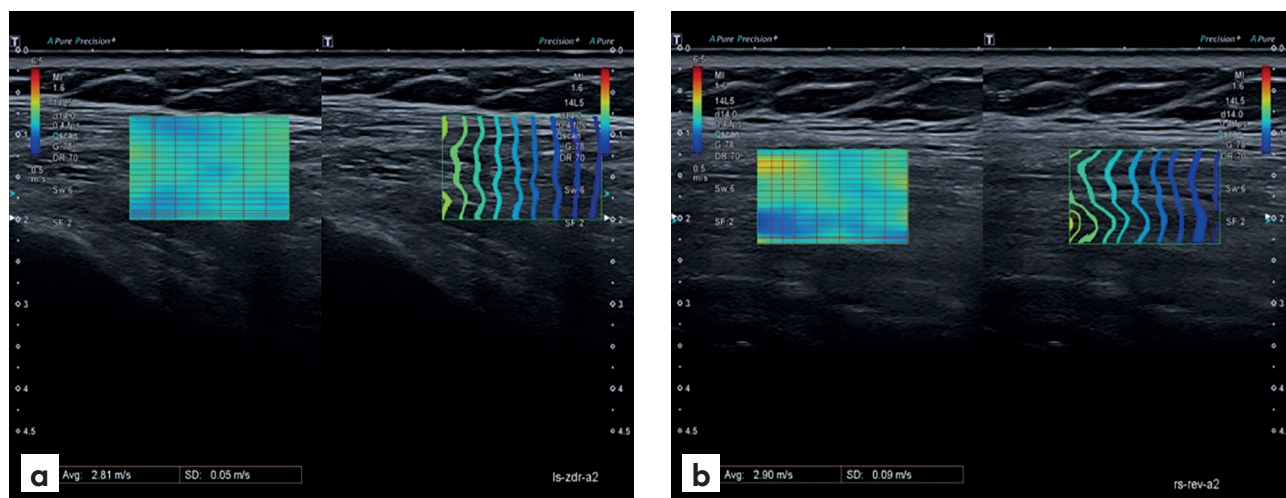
Ultrasonography a) Segment a [2], non-operated shoulder b) Segment a [2], operated shoulder.
